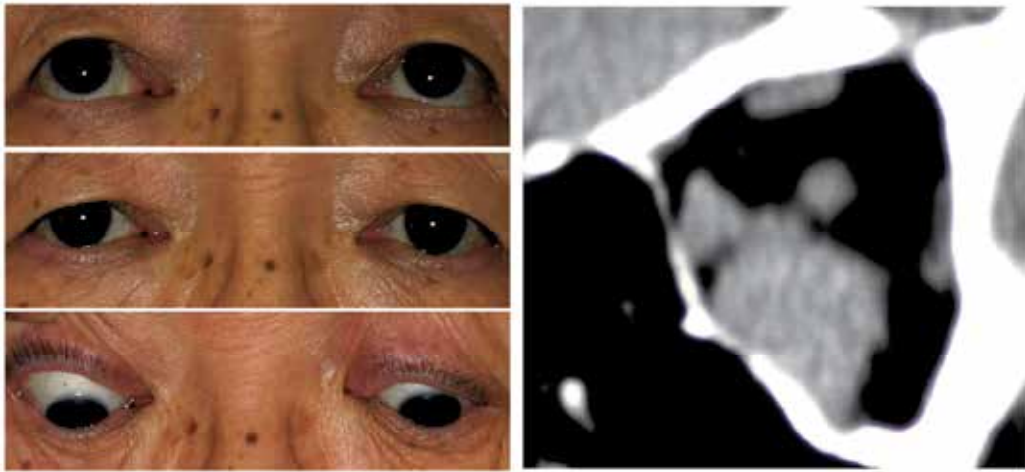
Secondary follicular lymphoma. CT image of the orbit of a 57-year-old man with a history of follicular lymphoma had extraocular enlargements. Note that ocular motility is within normal limits despite of extraocular enlargements.
